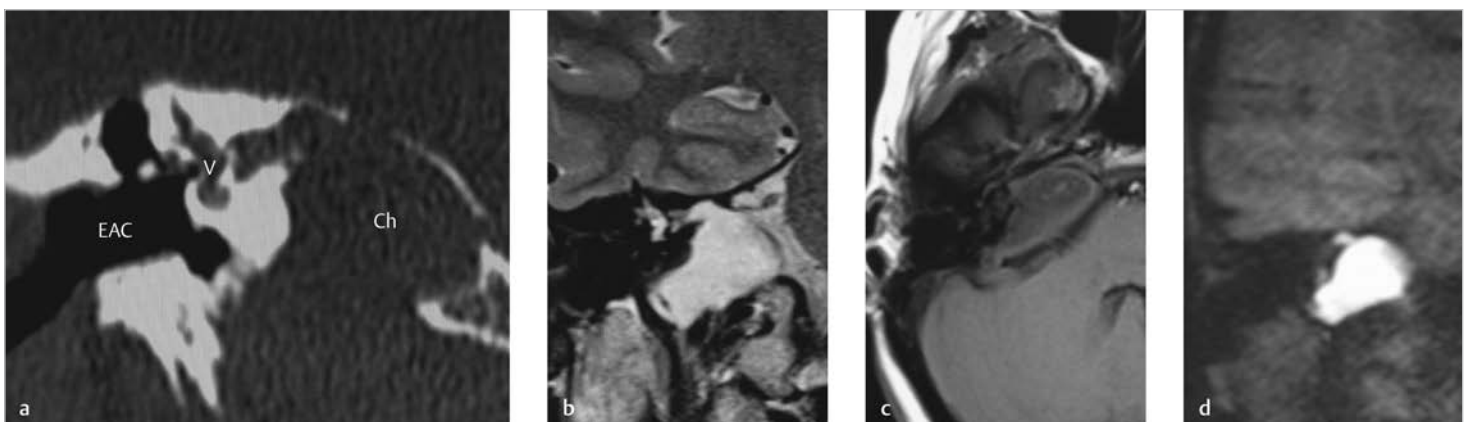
Infralabyrinthine-apical petrous bone cholesteatoma as shown in Case 14.19 in Chapter 14. The coronal CT (a) shows expansive growth of a large round-shaped lesion in the petrous apex. (b) The lesion shows high signal in T2 image, and (c) low in T1. (d) In diffusion-weighted image, very high signal corresponding with cholesteatoma is identified. Ch, cholesteatoma; EAC, external auditory canal; V, vestibule.
